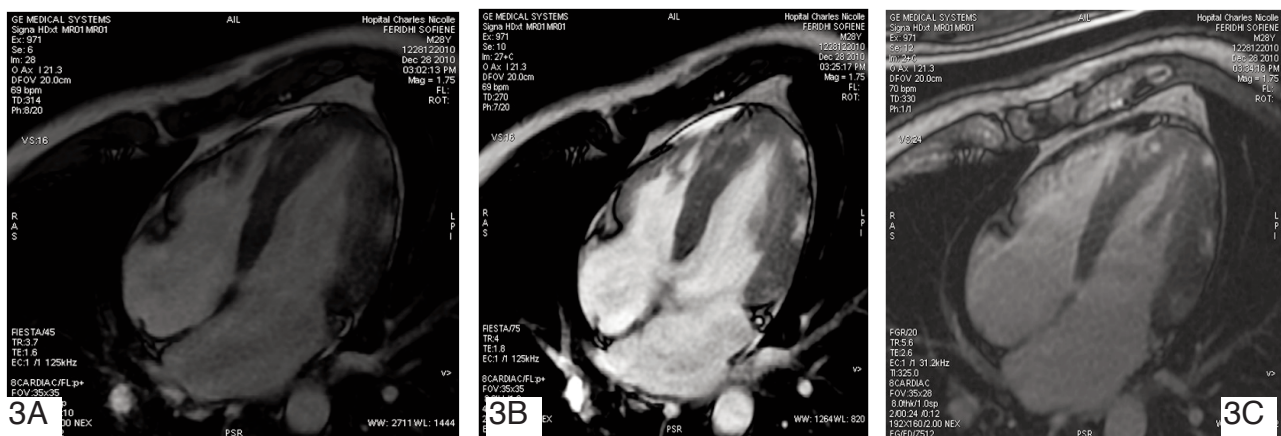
Acute myocarditis in a 28 year-old-male presenting with acute chest pain, fever and viral syndrome. Long axis views showing a close matching between the abnormalities on Cine MRI before injection (Figure 3 A), after injection (Figure 3 B) and on late Gadolinium enhancement sequence (Figure 3 C).Delayed enhancement is exclusively subepicardial, linear and patchy and predominates in the lateral wall of the left ventricle.
